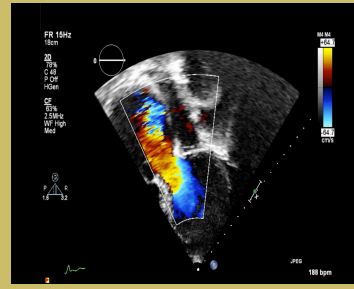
Still frame of the dilated ascending aorta and aortic root with color doppler over the aortic valve, showing severe aortic regurgitation on transthoracic echocardiogram in an apical five chamber view.
